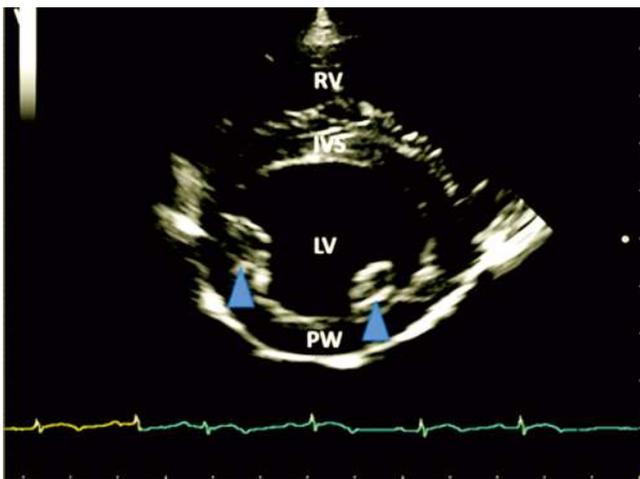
Parasternal short axis view at left ventricle with papillary muscles level (RV-right ventricle, IVS-interventricular septum, LV-left ventricle, PW-left ventricle posterior wall, the blue arrow heads-papillary muscles)
